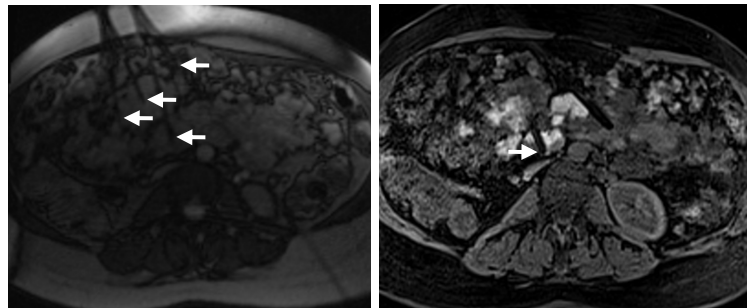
Axial abdominal MR views from 40 yo F with Klippel-Trénaunay-Weber syndrome, untreatable with ultrasound alone. Left: real-time BEAT IRTTT guiding multiple needles (arrows) targeting several deep-seated lesions. Right: a 15 cm needle (arrow) treating a VM residing adjacent to vena cava and other critical structures. Other treatment needles can be seen in this 3D VIBE. The bright areas highlight where STS/gad treatments have been injected.
